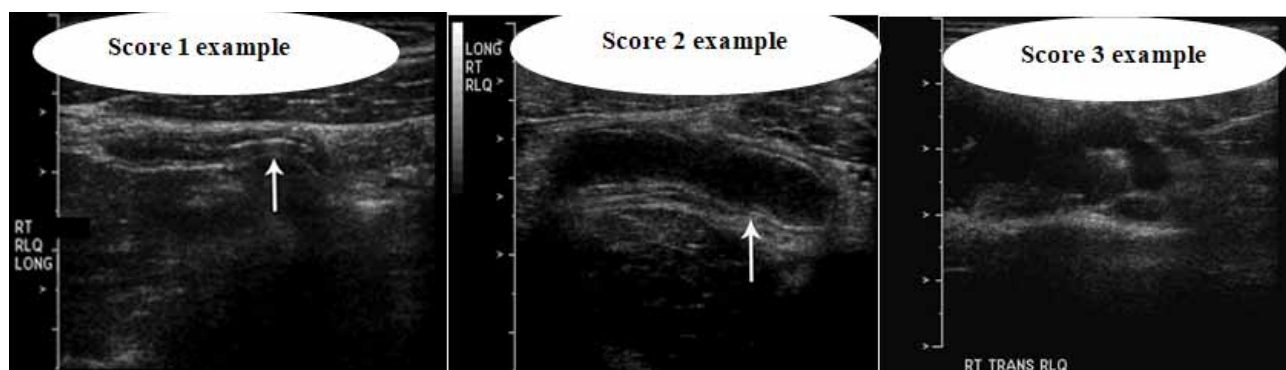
Ultrasound score 1-3.
